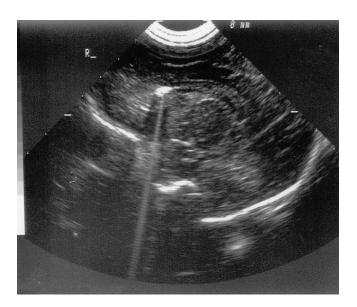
Cranial ultrasonography evidence of cerebral air embolisation. An echogenic density in the right lateral ventricle created acoustic shadowing with no through transmission.
